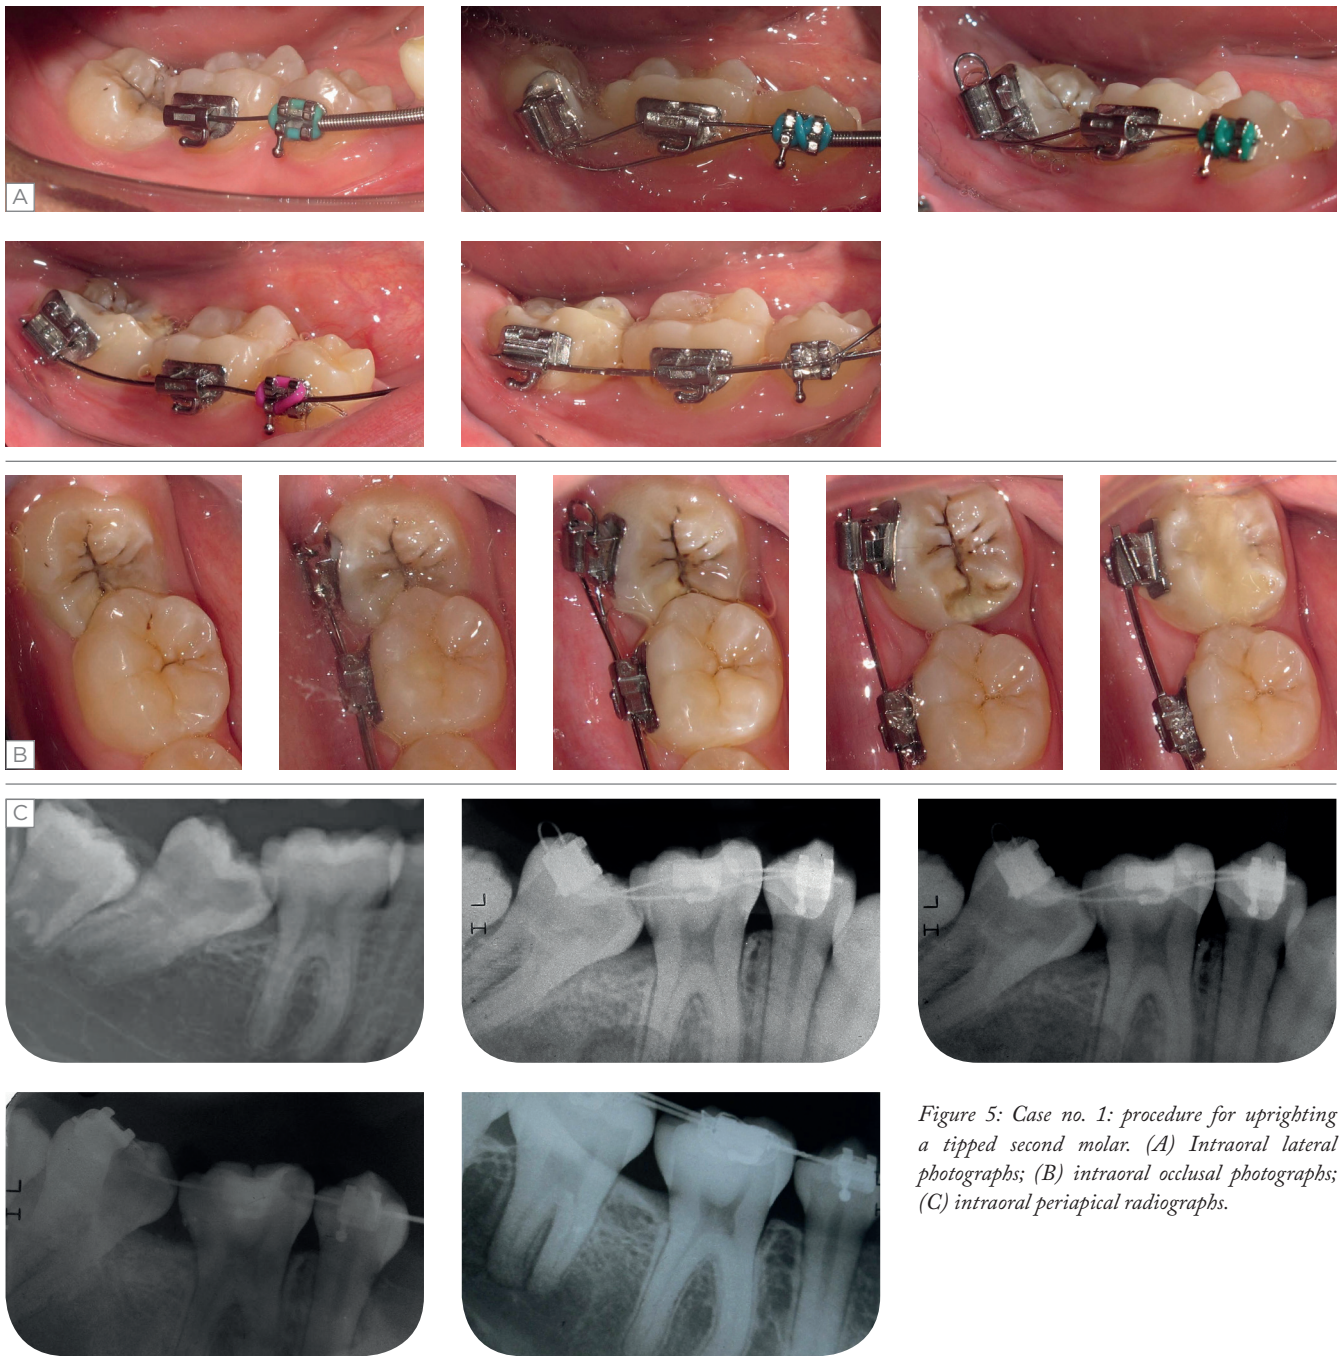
Case no. 1: procedure for uprighting a tipped second molar. (A) Intraoral lateral photographs; (B) intraoral occlusal photographs; (C) intraoral periapical radiographs.
